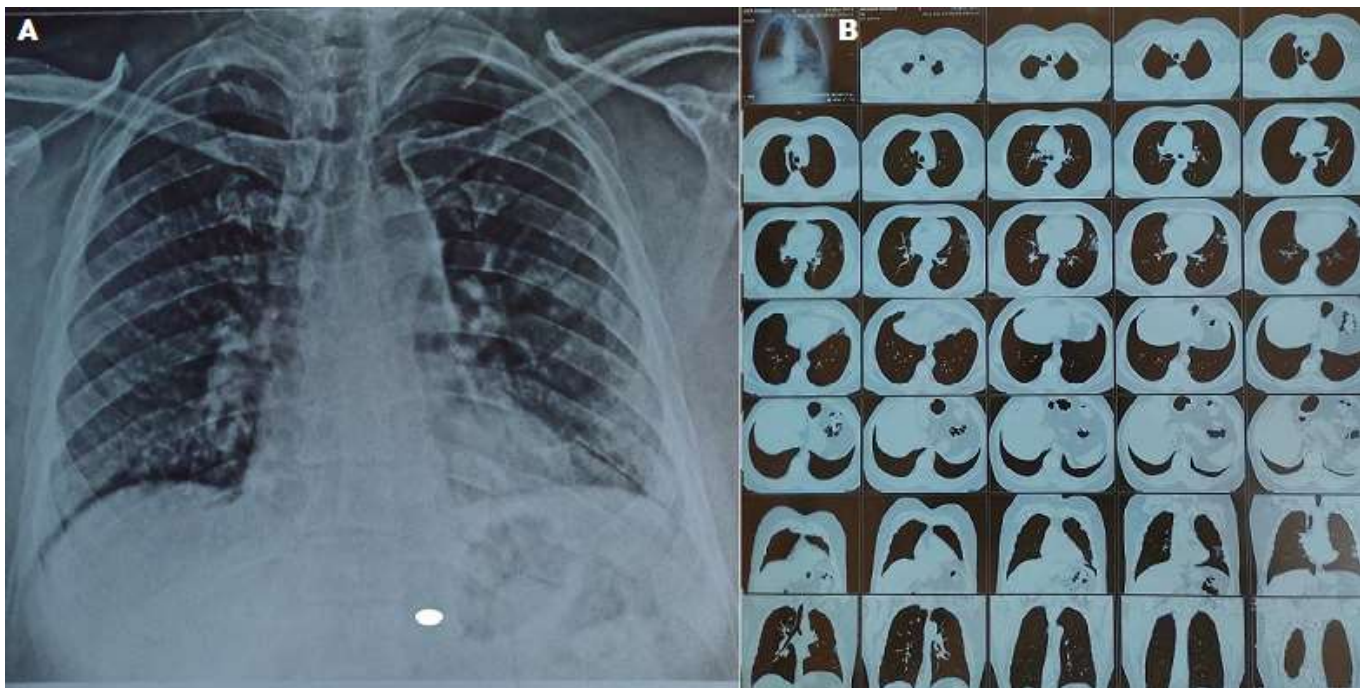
A) honeycomb appearance of bronchiectasis is evident in left upper lobe, posterior basal segment of left lower lobe, posterior segment of right upper lobe, and medial segment of right middle lobe; B) multiple peripheral ground glass opacities with interlobular septal thickening is evident in high-resolution computed tomography (HRCT)
